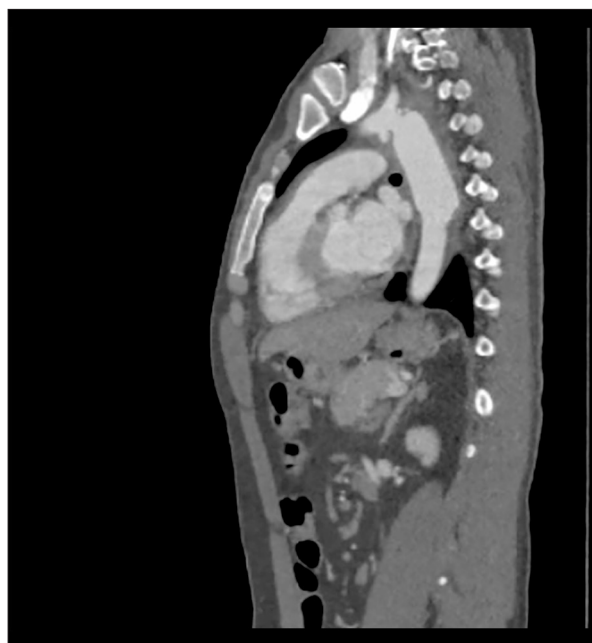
Computed tomography angiography (sagittal view) showing a periaortic hematoma, contrast extravasation, and a pseudoaneurysm at the inferior aspect of the proximal graft anastomotic site.
